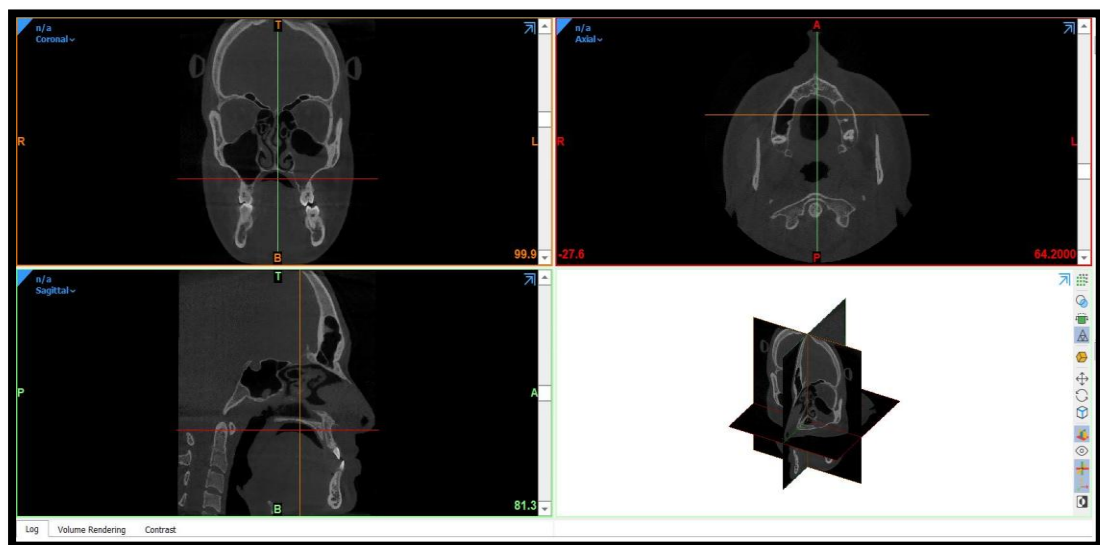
CBCT images of the maxillary and mandibular jaw
